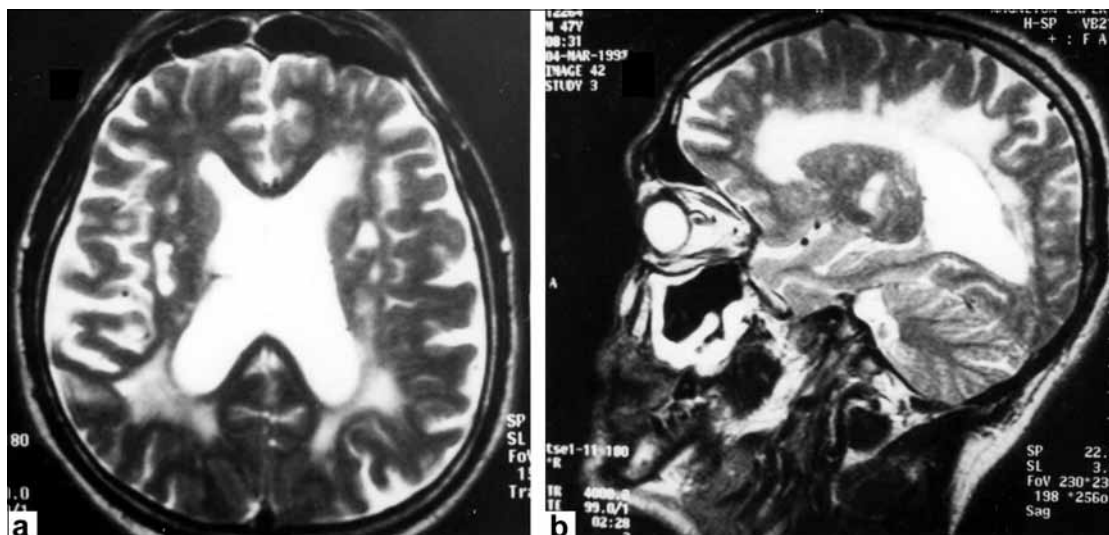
MRI T2-weighted brain images (a) axial scan; (b) sagittal scan; multiple areas of high intensity in subcortical and periventricular white matter
